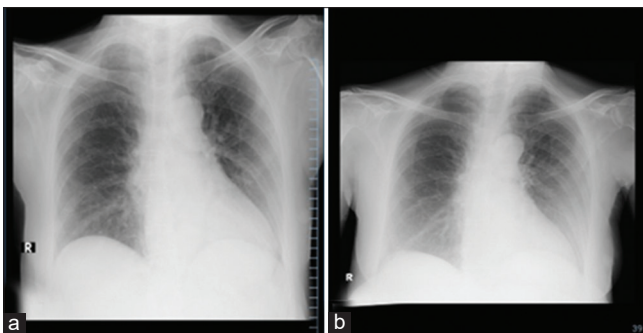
Chest X-ray of the first patient, (a) 1st day of admission; (b) 6th day after hospitalization
